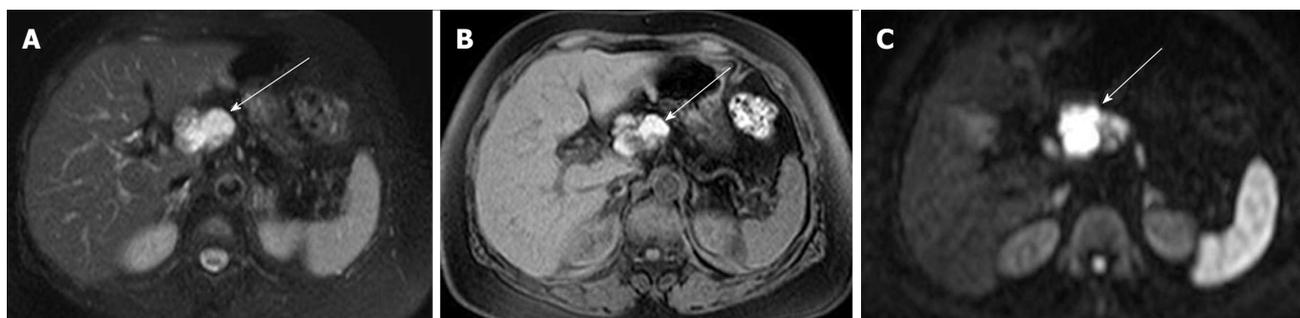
A 72-year-old female with pancreatic lymphoepithelial cyst. A: Axial T2-weighted fast spin-echo magnetic resonance (MR) image with fat saturation shows a high intensity mass (arrow), which is exophytic from the neck of the pancreas (not shown); B: Axial T1-weighted gradient-echo (GRE) MR image with fat saturation shows the mass to be high intensity (arrow). Findings on T2-weighted image (Figure 14A) may mimic microcystic serous cystic neoplasm (SCN). However, the widespread distribution of high signal is somewhat unlikely for hemorrhage within microcysts of SCN because each locule should be separated by multiple septations; C: Axial diffusion-weighted MR image (b-factor = 1000) shows the mass to be high intensity (arrow), unlikely for SCN.
